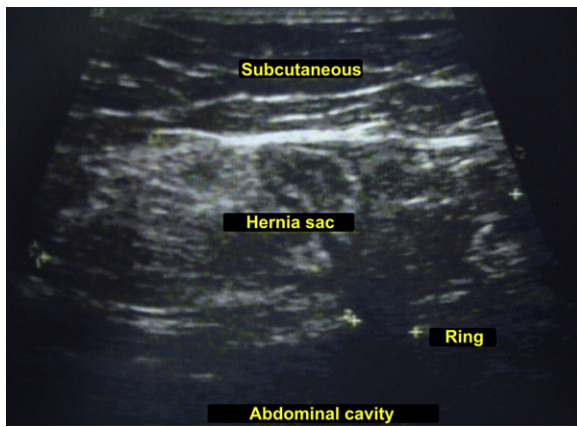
Abdominal wall ultrasound showing Spigelian hernia.
